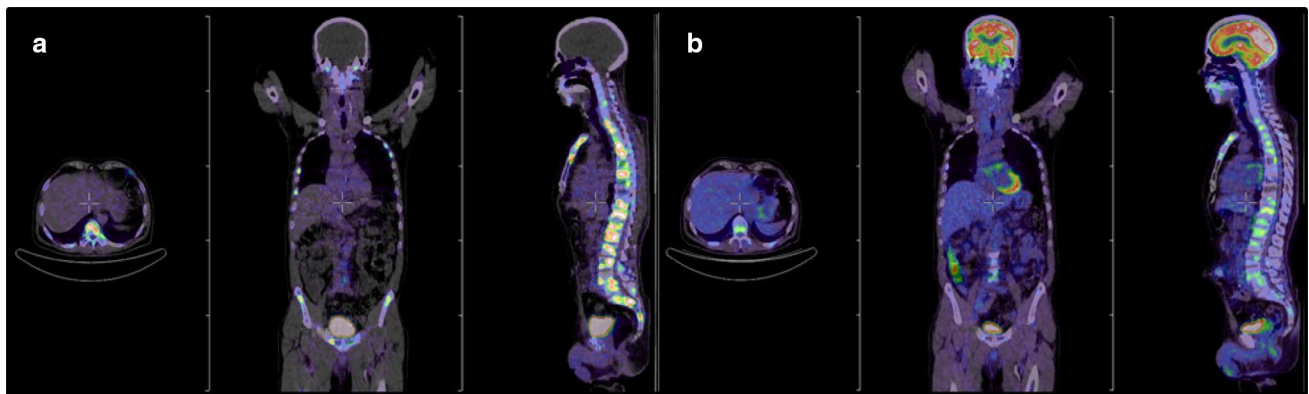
Comparison of PET/CT images of a. $[^{68}\text{Ga}]\text{Ga-DOTA}^{\text{ZOL}}$ with b. $[^{18}\text{F}]\text{FDG}$ in patient with skeletal metastases secondary to bronchial carcinoma.
